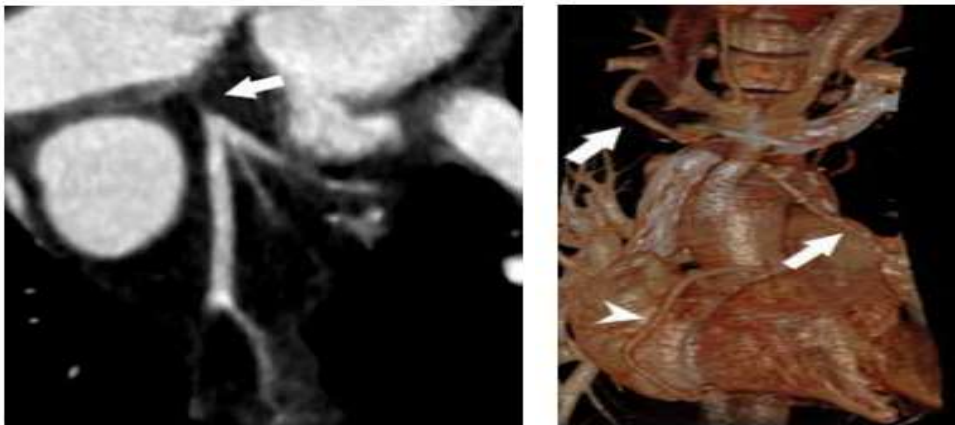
A. Coronary CT angiography in patients with Takayasu's arteritis type II. Occlusion of the main trunk of the left coronary artery (arrow, LM - left main). B. Coronary atresia (LM) bypass of the right internal mammary artery (RIMA). Properly passable right coronary artery (head arrow)
